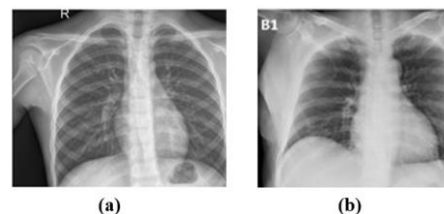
Samples of chest X-ray images (a) normal and (b) COVID-19
